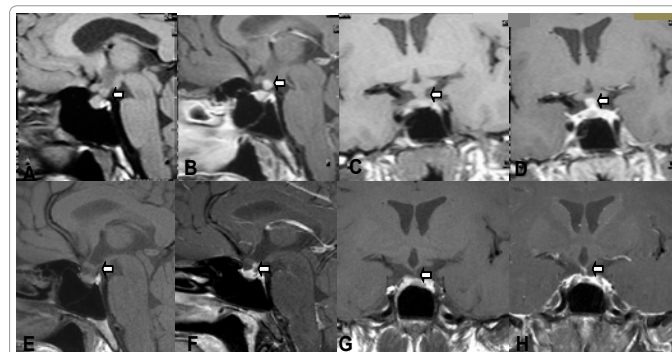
Pituitary stalk thickening at diagnosis and decreased size of the pituitary stalk after a 6-year follow up. Magnetic resonance imaging of pituitary at the diagnosis revealed an enlarged pituitary stalk of 7 x 6 x 5 mm (arrow) with a demonstrated posterior bright spot. A and B) T1W sagittal view without and with Gadolinium, respectively; C and D) T1W coronal view without and with Gadolinium, respectively. Magnetic resonance imaging of pituitary 6 years after diagnosis demonstrated a reduction in the size of the pituitary nodule at pituitary stalk from 7 x 6 x 5 mm to 2 mm. (arrow) and loss of posterior bright spot. E and F) T1W sagittal view without and with Gadolinium, respectively; G and H) T1W coronal view without and with Gadolinium, respectively.
